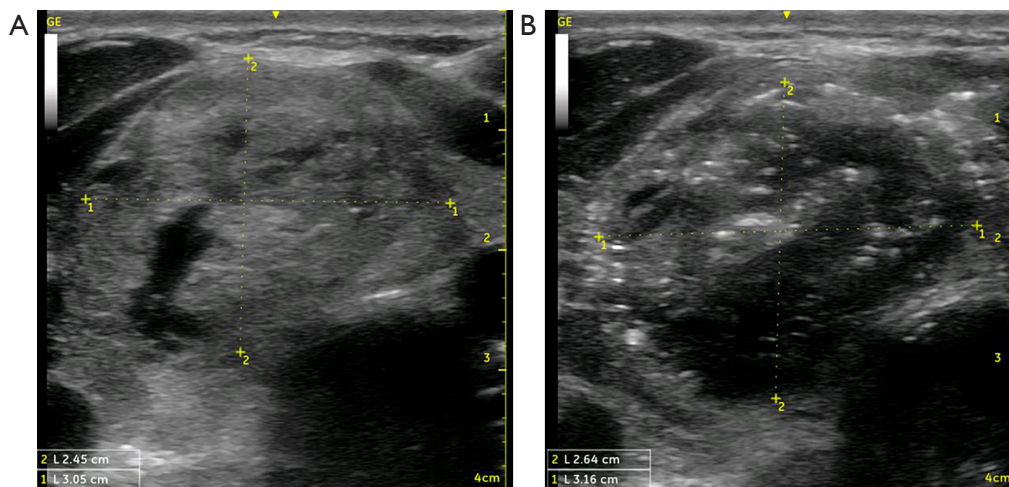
Ultrasound of a benign nodule with reduced margin of unablated tissue to increase the IAR (A) Initial aspect of an Isoechoic nodule before RFA and (B) final aspect of the nodule after ablation. Also demonstrate the completeness of the treatment. IAR, initial ablation rate; RFA, radiofrequency ablation.
